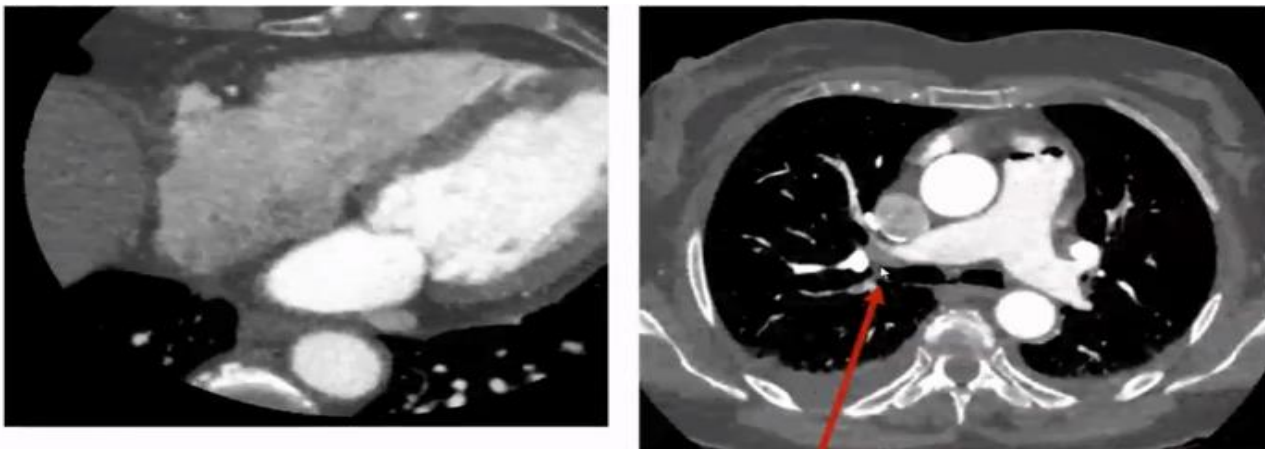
Chest CT images with contrast; computed tomography angiography (CTA) show pulmonary embolism (red arrow) (Grillet et al. 2020).
